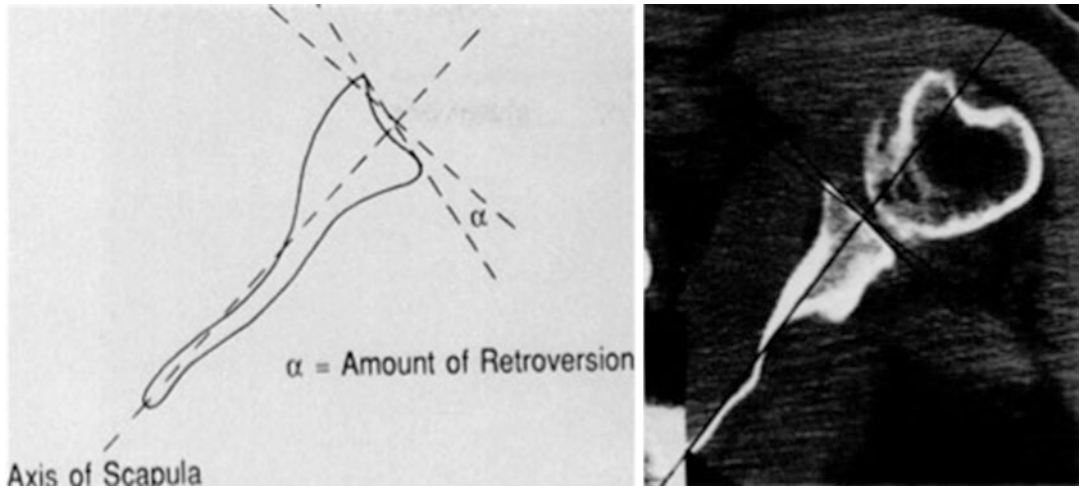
Friedman method to measure glenoid version. The Friedman method utilizes an axial CT image at the mid glenoid with retroversion measured utilizing the angle between the scapular axis and the plane of the glenoid (α). (Adapted from Friedman et al. [4])
